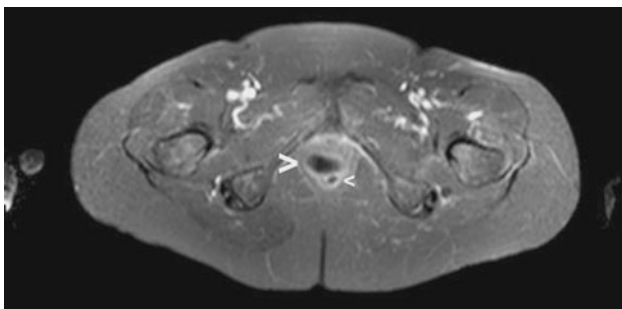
Coronal MRI revealed a mass within the rectal wall (*big arrow*) deforming the rectal lumen (*small arrow*)
